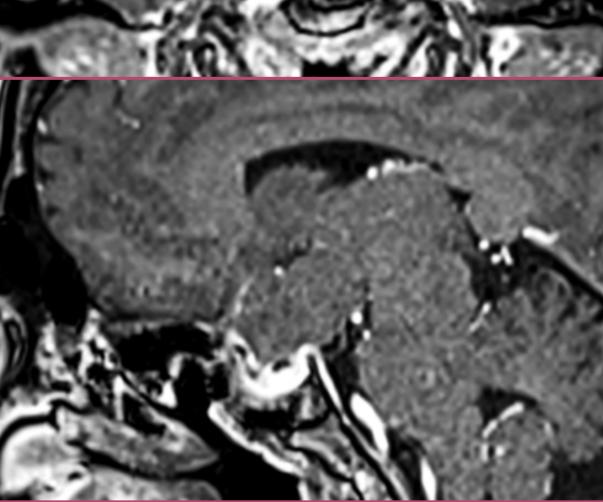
Axial, coronal and axial view of contrast T1-weighted MRI brain after the first operation showed a residual cystic suprasellar lesion
